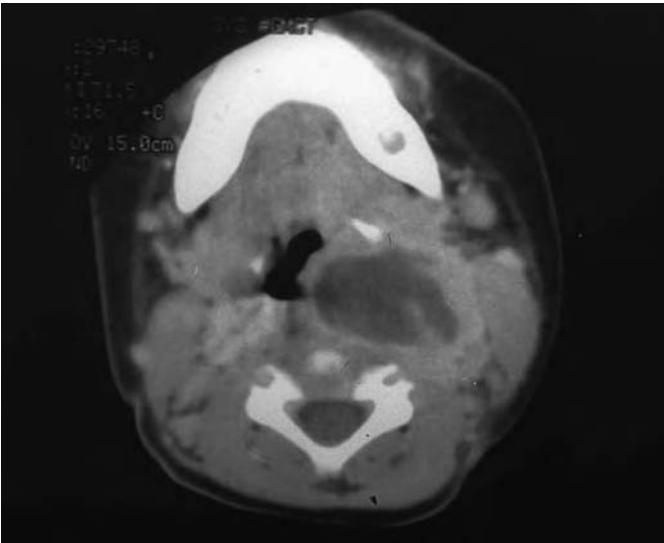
A CT scan of the patient's neck, showing a large retropharyngeal abscess.*
